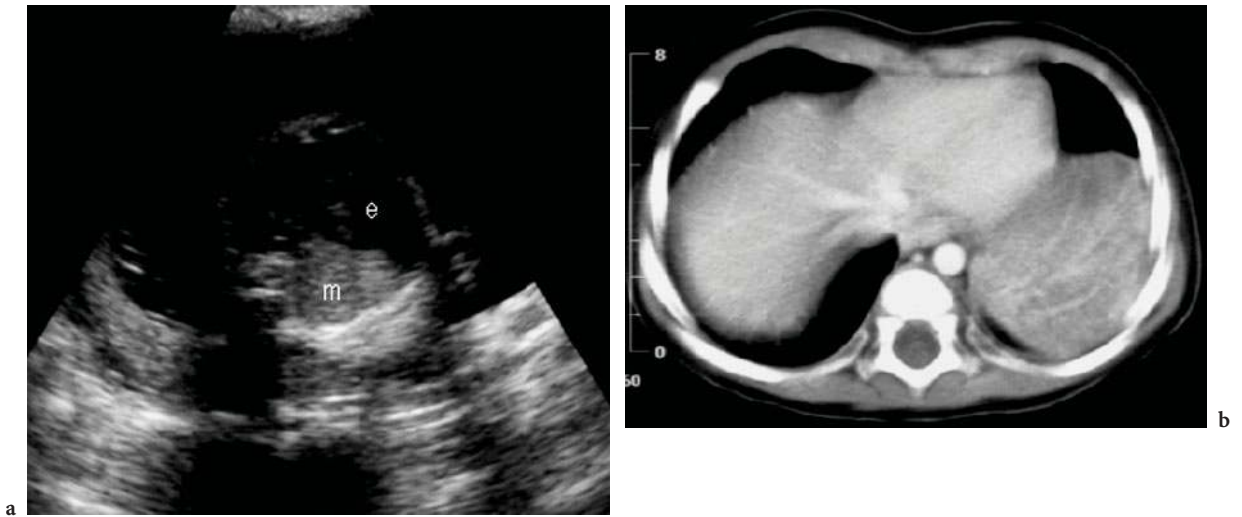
Left pulmonary sequestration associated with antenatal ipsilateral hydrothorax (*e* effusion, *m* mass). a In utero at 20 weeks (transverse scan). b Post-natal CT at 8 months of age, showing the sequestration
